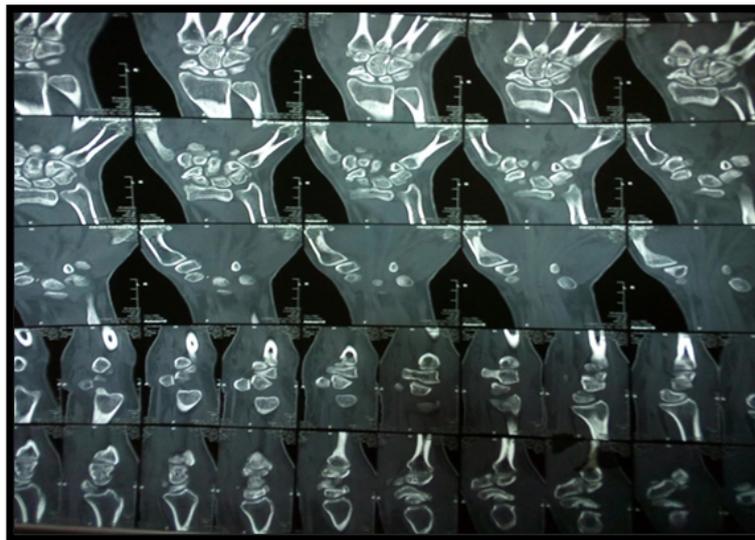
CT of the left wrist.
